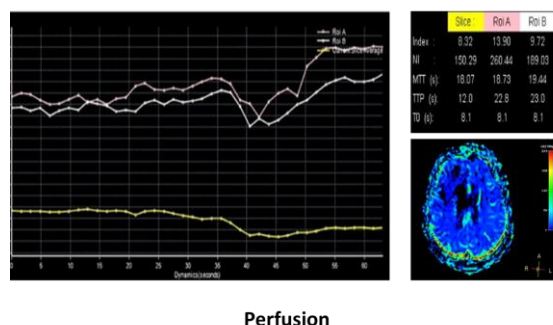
DCE T1 perfusion MRI after gadolinium reveals a low rCBV, rCBF and MTT value within the tumour with characteristic time-intensity curve overshooting the baseline
